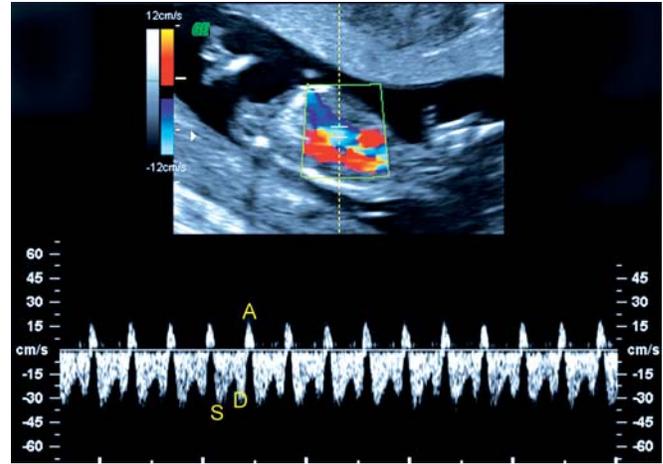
Reverse a wave in ductus venosus spectral Doppler in a case of trisomia 21
